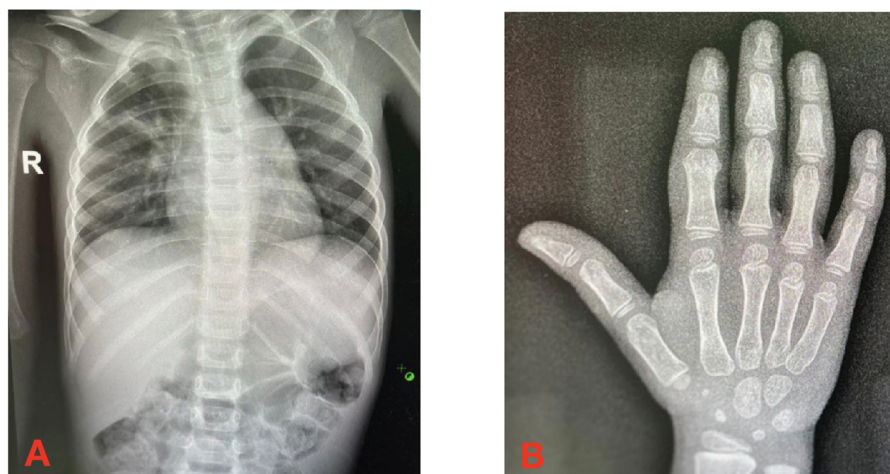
A: Follow-up chest X-ray, taken 9 months after the initiation of anti-TB therapy, showing significant improvement in the right lung opacity. B: Follow-up hand X-ray, taken 9 months after starting anti-TB therapy, showing restoration of normal bone structure.
